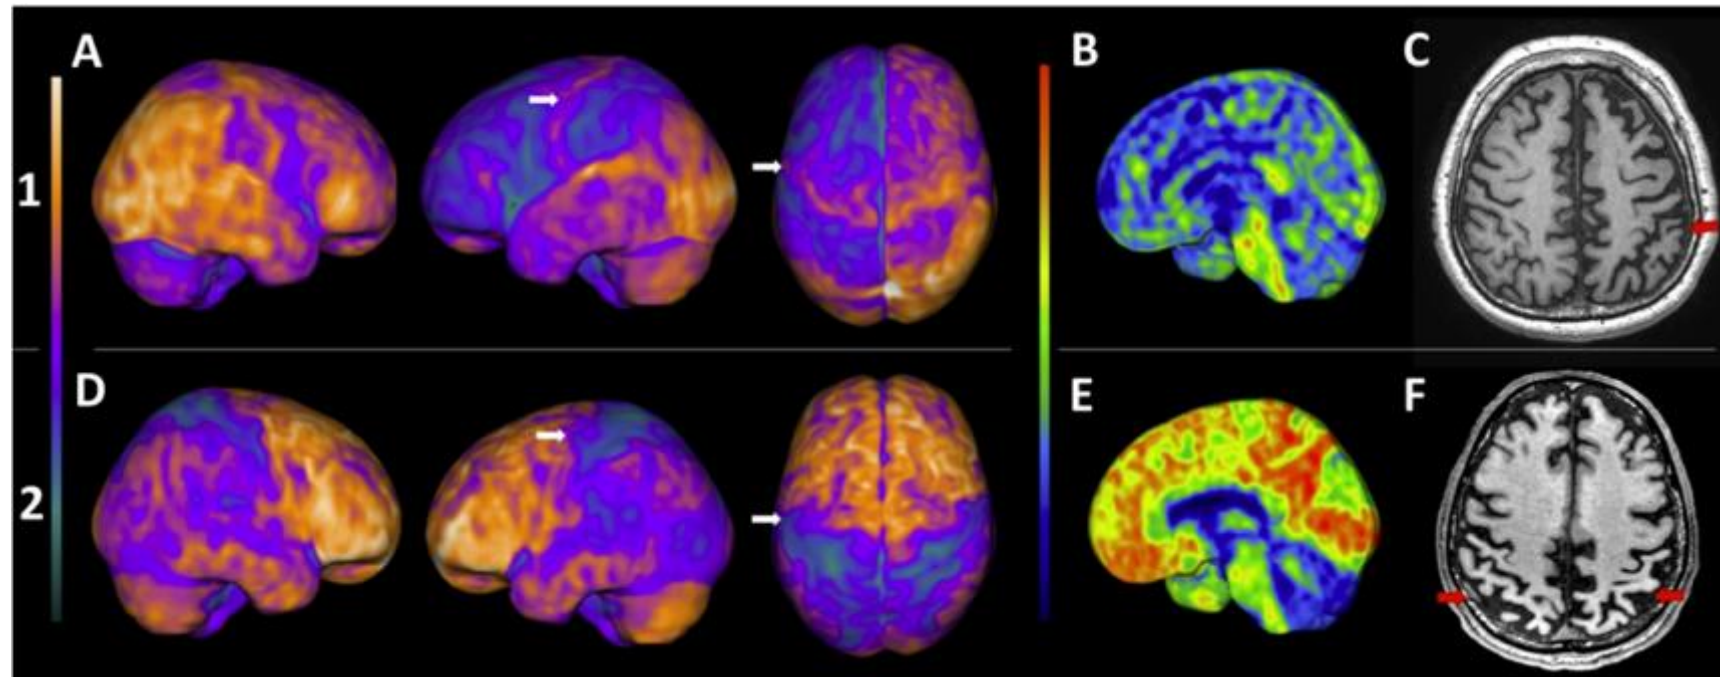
FDG-PET, PIB-PET and MRI in two patients presenting foot-hand synkinesis
